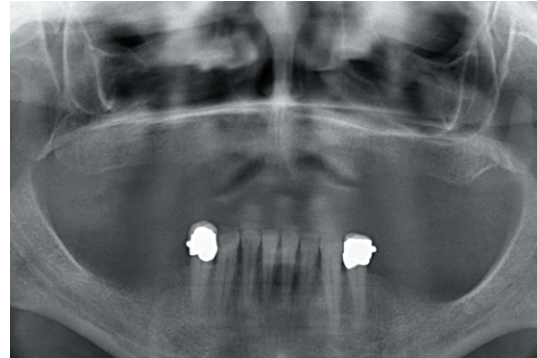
Initial panoramic X-ray showing the approximate maxillary and mandibular bone ridge heights for a first diagnostic impression.
